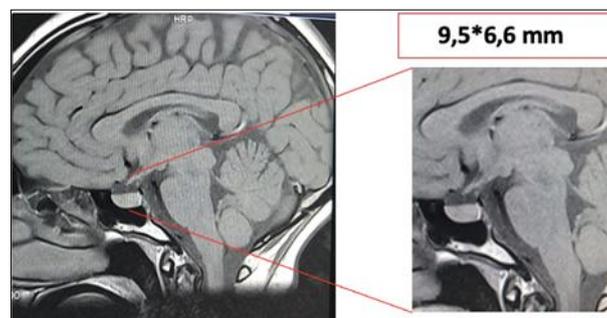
MRI coronal plan before pregnancy
